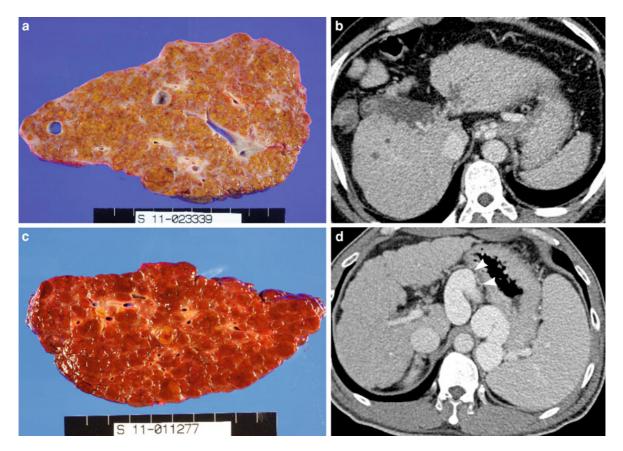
Cirrhosis: pathologic and CT findings. a Micronodular cirrhosis in a patient with alcoholic cirrhosis. b Corresponding CT image of micronodular cirrhosis. c Macronodular cirrhosis
